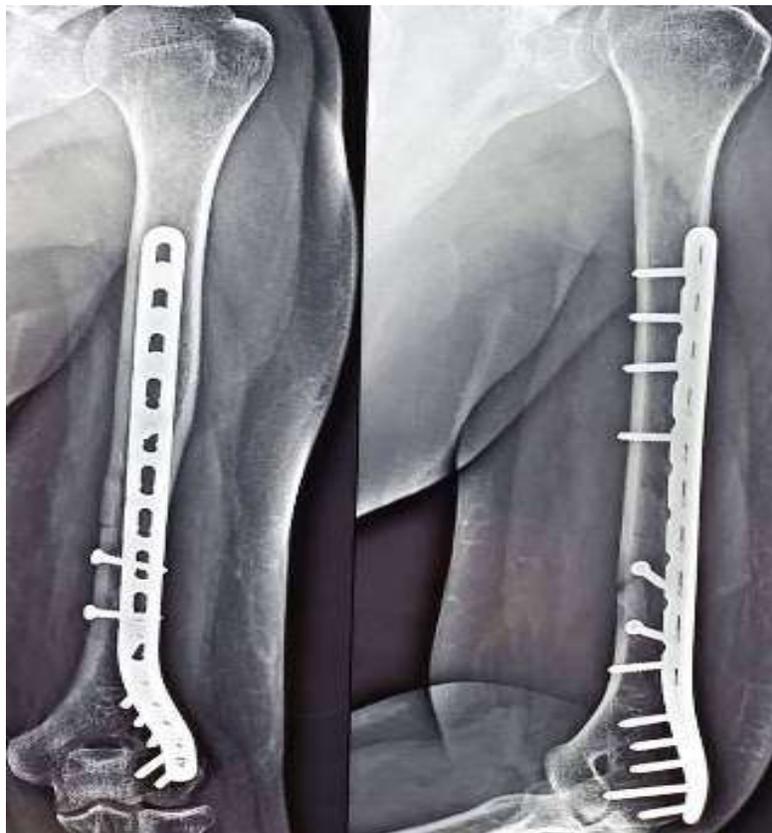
Final follow-up x-ray image showing Anatomical reduction & Radiological Union
